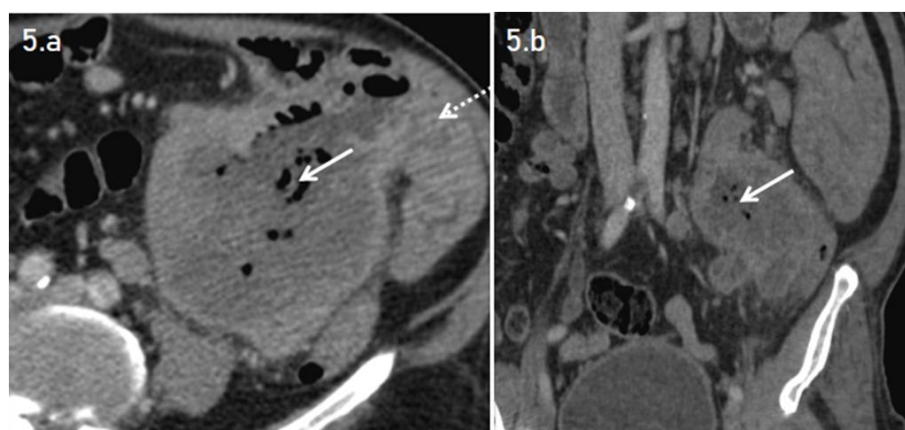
(a & b): 63-year-old case with malignant jejunal GIST Axial (a) and coronal (b) views of contrast-enhanced CT study of abdomen in venous show a large heterogeneous mass
